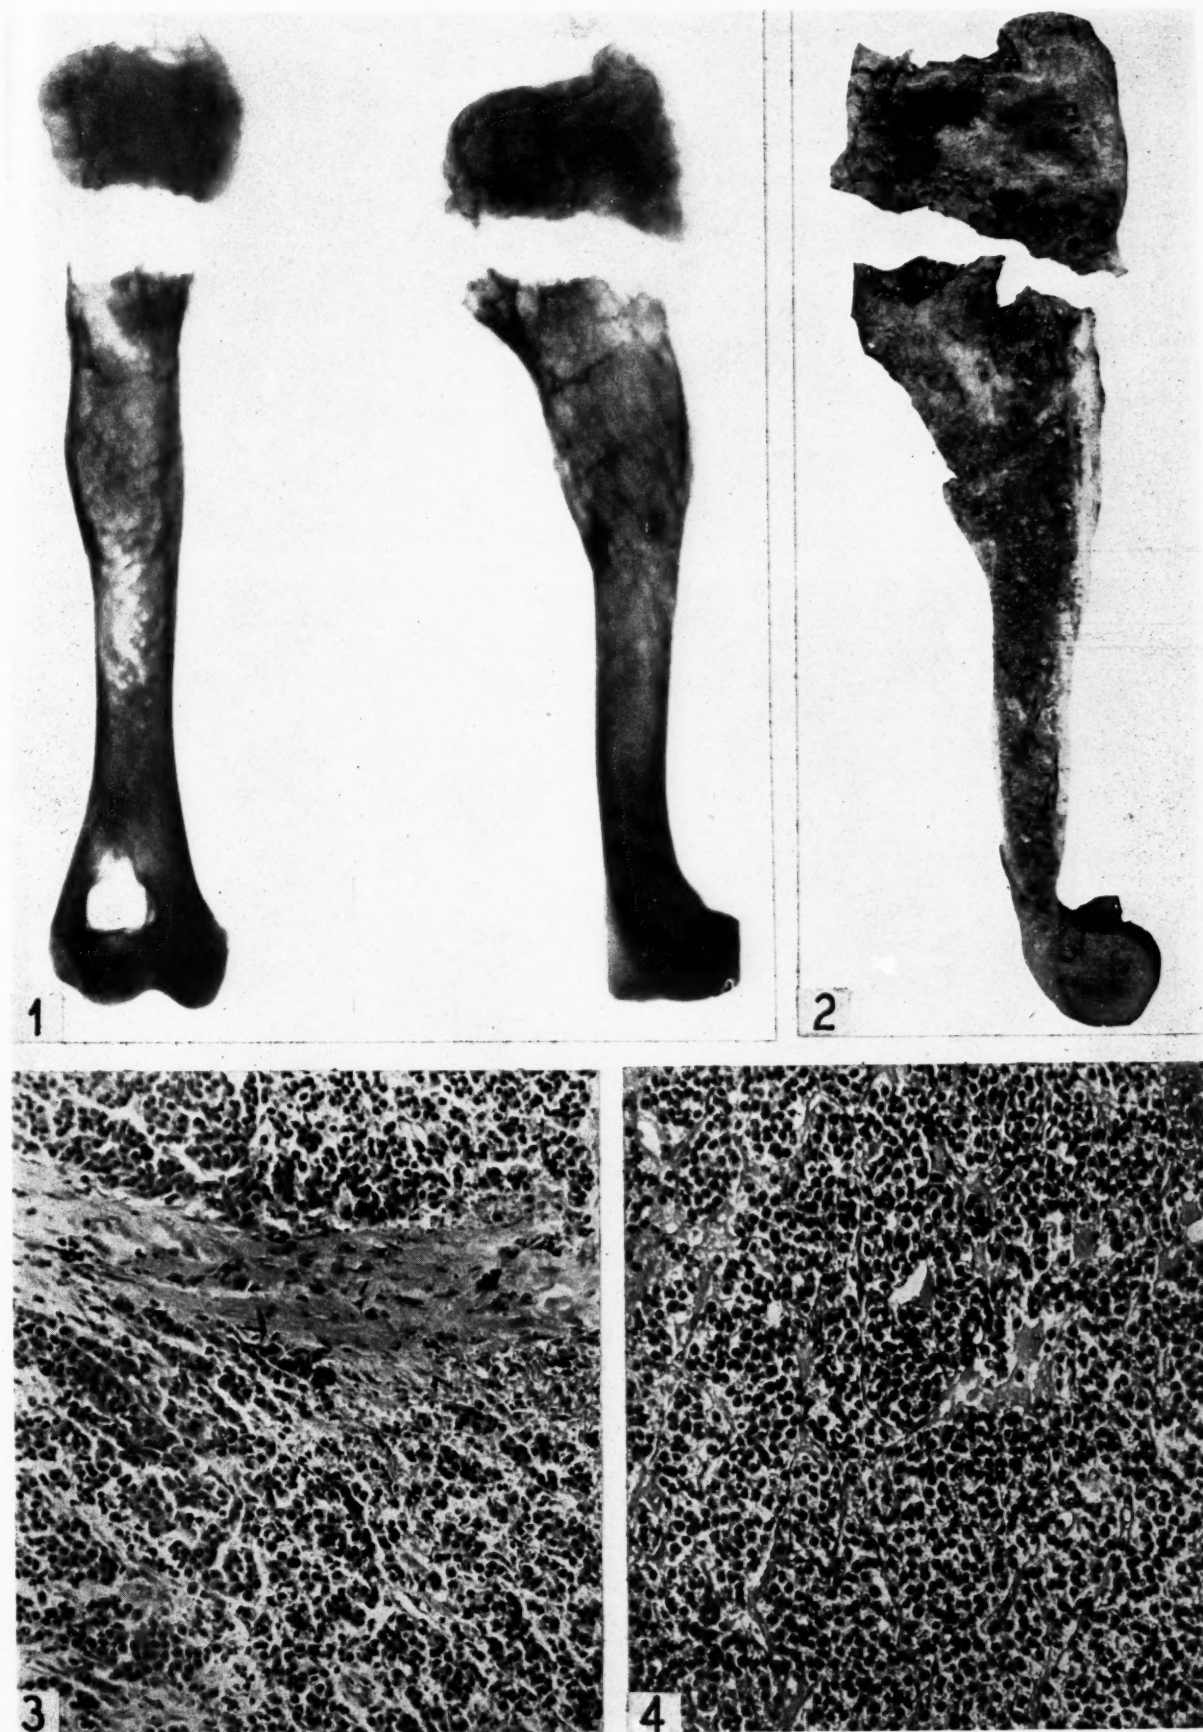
Radiographic appearance of plasma cell myeloma involving the upper two-thirds of left humerus.
